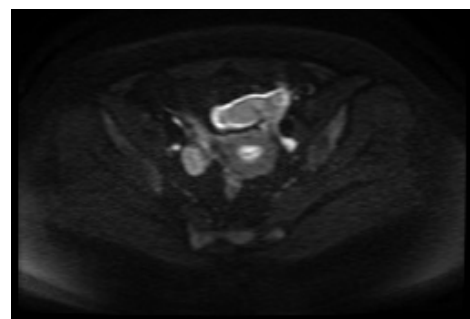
Axial contrast CT at the level of pelvis showing fluid filled dilated tubular structure with wall enhancement at left adnexa with surrounding inflammatory changes
